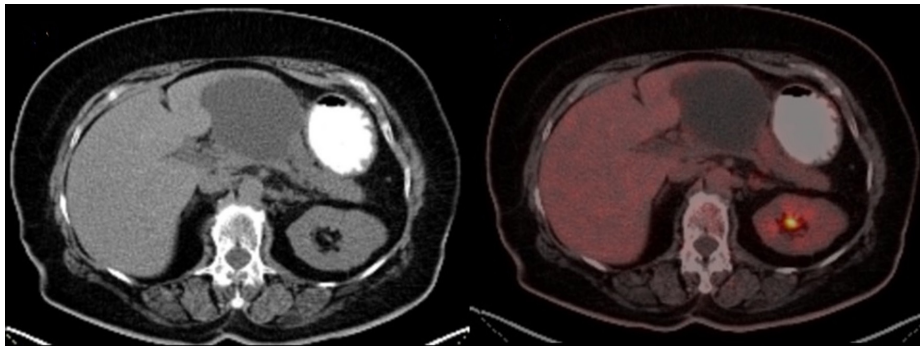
PET-CT; no suspicious FDG avid lesion observed; 9 x 8 cm cystic lesion consistent with a pancreatic pseudocyst observed in the mid abdomen. PET-CT, positron emission tomography-computed tomography; FDG, fluorodeoxyglucose.
